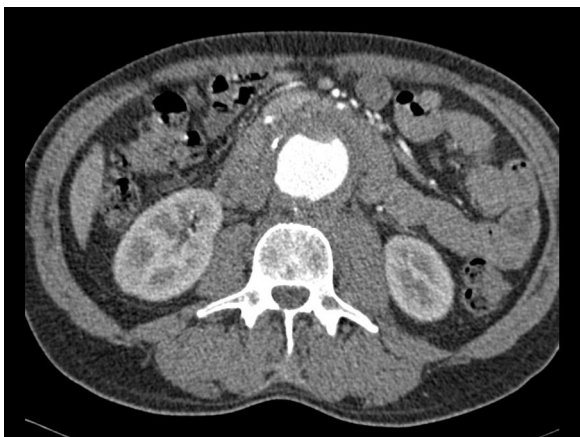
Preoperative CT angiogram showing a 5.8 cm inflammatory abdominal aortic aneurysm.
